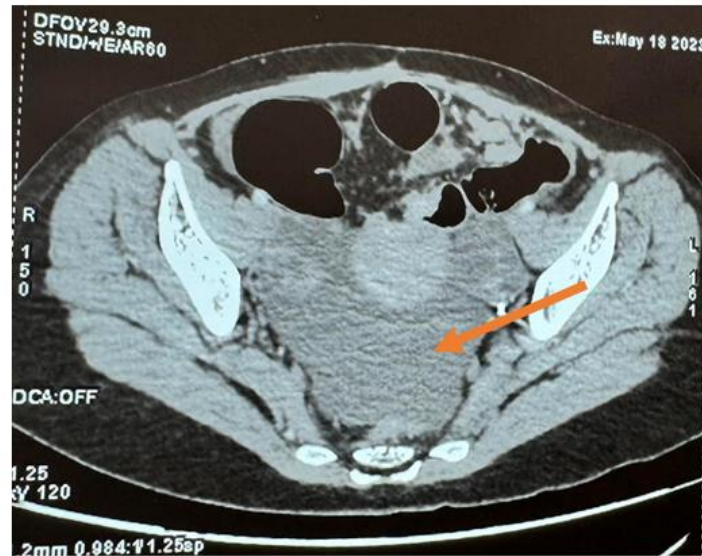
Abdominal CT showing mass at the dome of the bladder
